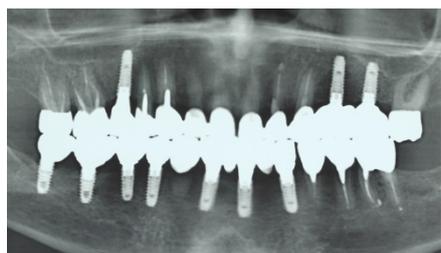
Panoramic x-ray after treatment
